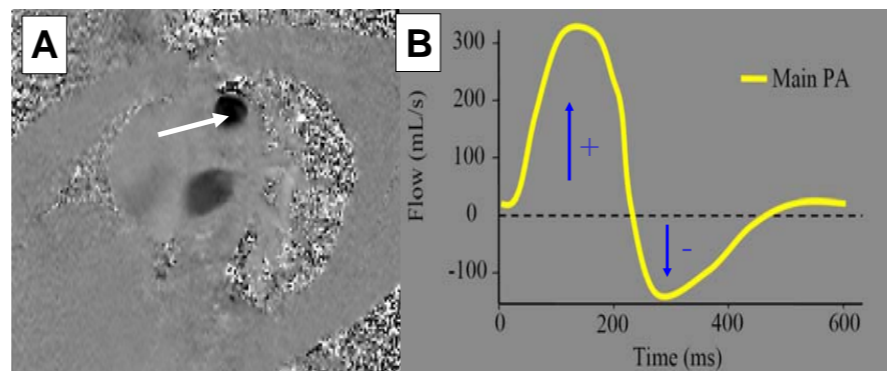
A: Phase-contrast MR image of a patient with significant pulmonary regurgitation, indicated in black (arrow). B: Representative mapping of pulmonary flows.
